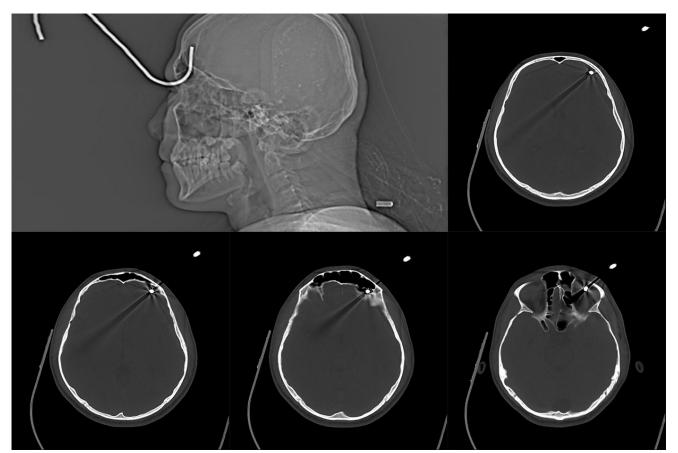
Non-contrast CT scan of head in axial plane showing pneumocephalus and the foreign body.
